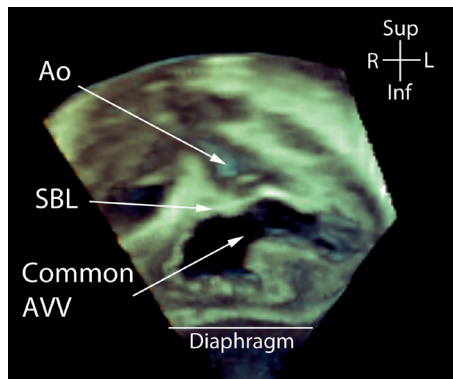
Transthoracic 3DE en face view of atrioventricular septal defect. En face view of a complete atrioventricular septal defect from the ventricular aspect, obtained using a subcostal view. The depth of field means that the superior bridging leaflet and the common atrioventricular valve are seen as well as the aorta in the far field. Ao, aorta; SBL, superior bridging leaflet; AVV, Atrioventricular valve.
